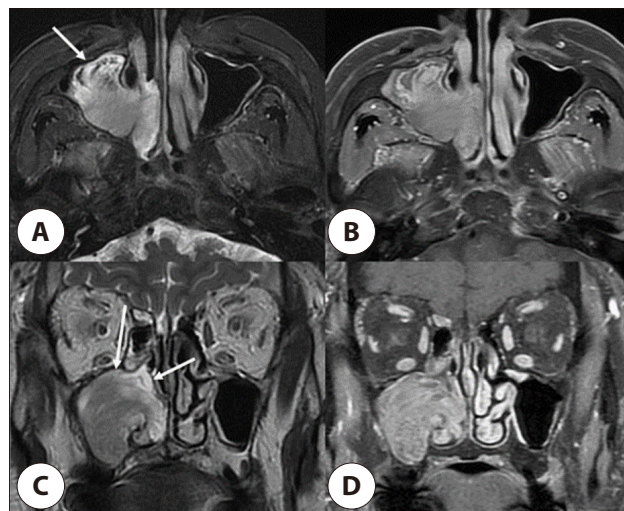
A 67-year-old female with inverted papilloma originating from the posteroinferior wall of the left maxillary sinus. Axial (A) and Coronal (C) T2WI show peritumoral hyperintense layers at the anterior, superior, and medial portions (arrows) of the mass, but not at the posteroinferior portion of the maxillary sinus. Axial (B) and Coronal (D) Gd-T1WI demonstrate contrast enhancement in both the mass and peritumoral edematous mucosa, obscuring the mass origin. T2WI: T2-weighted image, Gd-T1WI: Gd-enhanced T1-weighted images.
